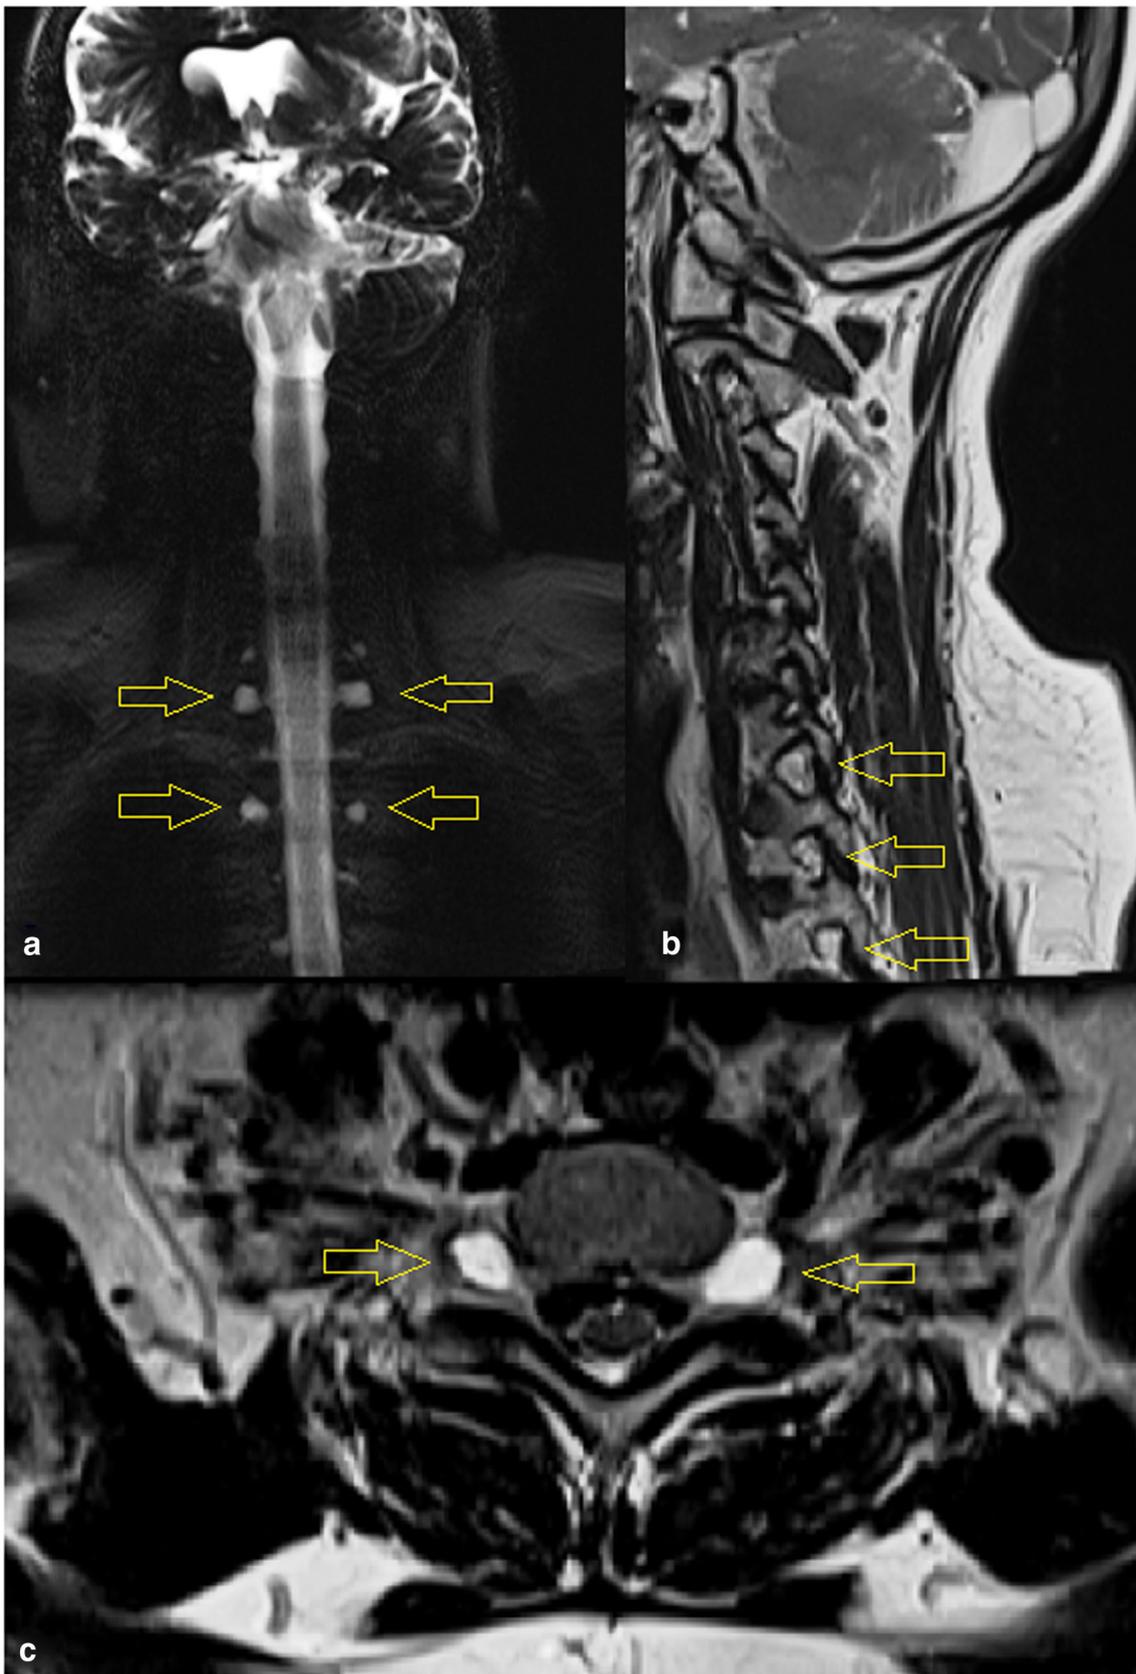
Magnetic resonance imaging showing multiple (C7–T1) spinal root cysts (a). T2-weighted sagittal (b) and axial (c) images depicting hyperintense lesions (yellow arrows point to the lesions)
